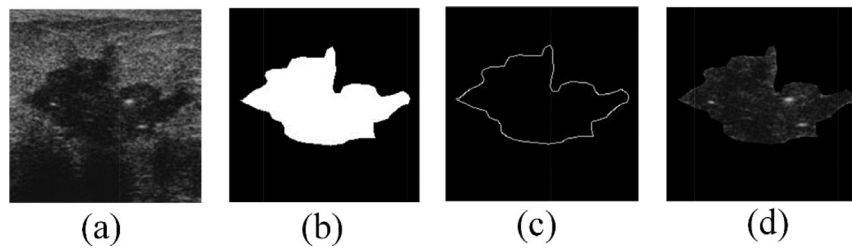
Edge and lesion extraction: (a) Original breast ultrasound image; (b) Mask image; (c) Edge complexity image; (d) Lesion image
